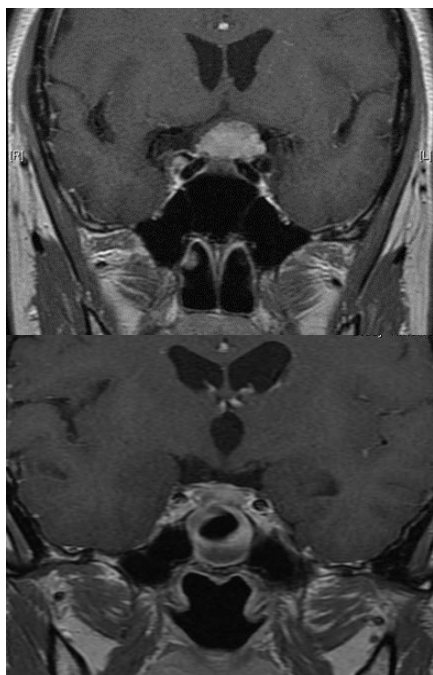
Preoperative and 6 month's postoperative coronal MRI images for tuberculom sellae meningioma in 30 years old female patient
